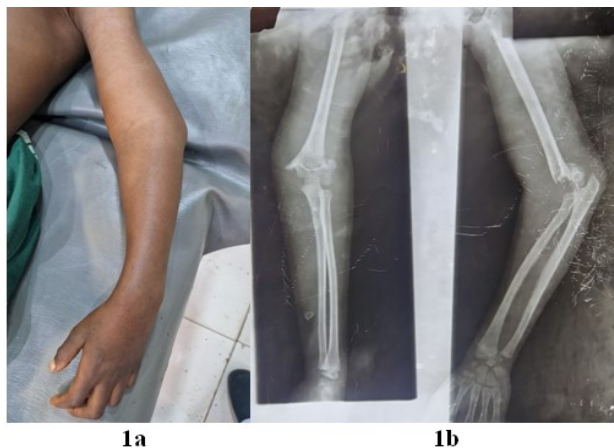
A 9 year old female patient with 16 hour injury to the left elbow (1a). Xray (1b) showed displaced supracondylar fracture of the humerus
